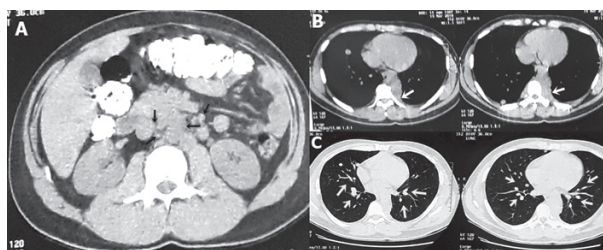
Computed tomography with contrast. A: lymph node enlargements represented by black arrows; B: white arrows representing the tissue material of soft parts in the posterior mediastinum; C: white arrows representing the pulmonary nodes
